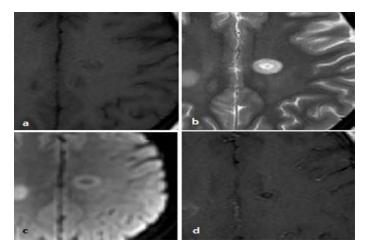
Callosal lesion is iso/hypointense on T1-weighted (a) and iso/hyperintense on T2-weighted (b) images. On diffusion weighted image (c), hypointense central core of the lesion is surrounded by a hyperintense ring. Following gadolinium administration, the lesion shows a minimal enhancement which is difficult to distinguish (d).
